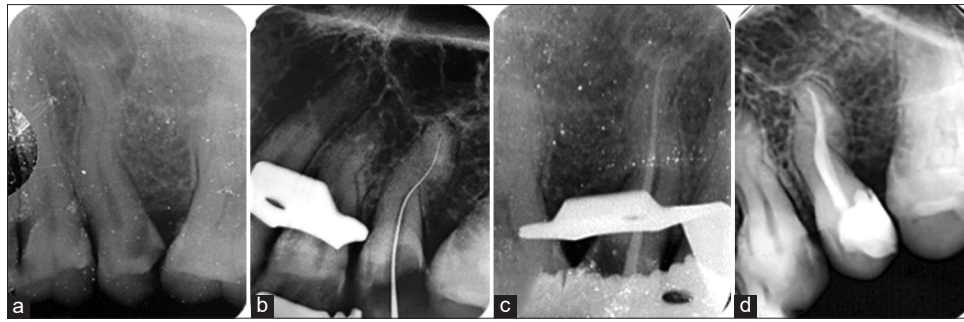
Endodontic management of permanent left maxillary premolar (Tooth #25). (a) Pre-operative radiograph, (b) WL radiograph, (c) master cone radiograph, and (d) post-obturation radiograph
